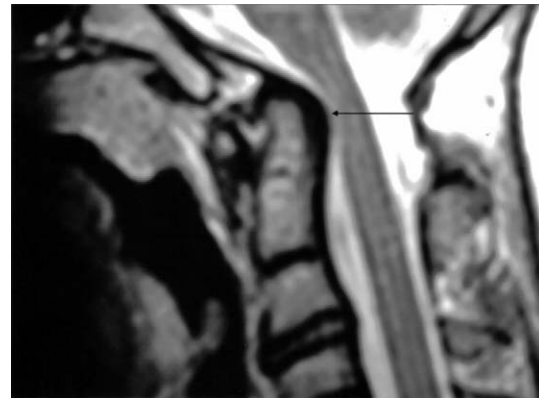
MRI scan of the same patient showing rupture of transverse ligament and compression of the dura mater space.
